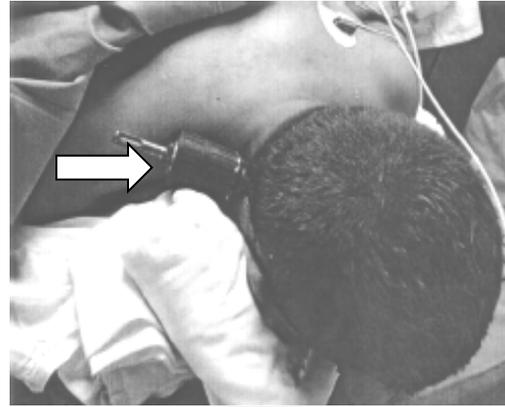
The neck-injured patient in prone position with a 6mm diameter drill bit (arrow) protruding from the right side of the neck (a) and the lateral cervical radiography showed that the drill bit's distal extremity (arrow) had entered the spinal canal (b). (Reproduced from Valero R et al ⁽⁷⁾, with permission).
